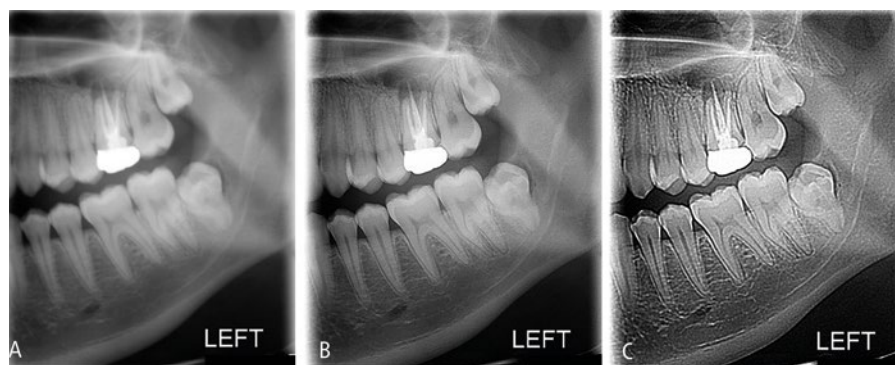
a) Example of extraoral bitewing with no post-processing. b) Same image with one sharpen. c) Same image with multiple sharpens
